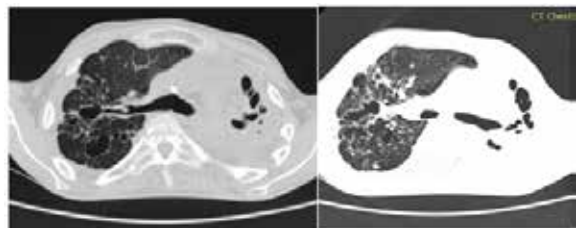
(a) Thin section Axial CT and (b) HRCT image of a single patient aged 29yrs on MDR-TB treatment since 10 months showing complete collapse of left lung with massive pleural thickening and cystic bronchiectasis. Thin walled cavities also noted communicating the right upper lobe bronchus in image (a).
